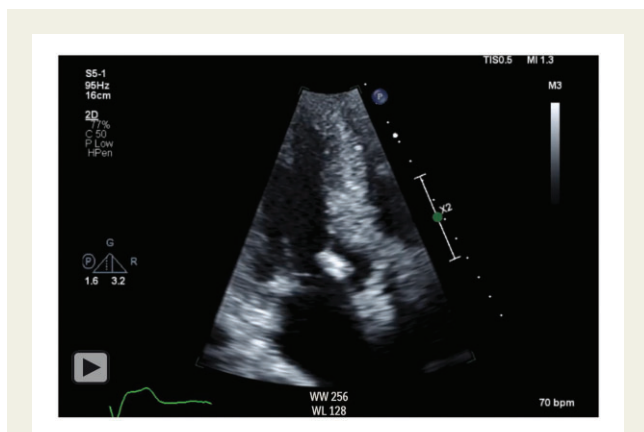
Comparison transthoracic echocardiograms intra- and post-alcohol septal ablation therapy. (A) Immediate post-ablation view of interventricular septum. (B) Spectral Doppler view with marked peak gradient at time of ablation therapy. (C) D1 post-ablation view of interventricular septum. (D) Spectral Doppler view with improved pressure gradient D1 post-ablation therapy.
